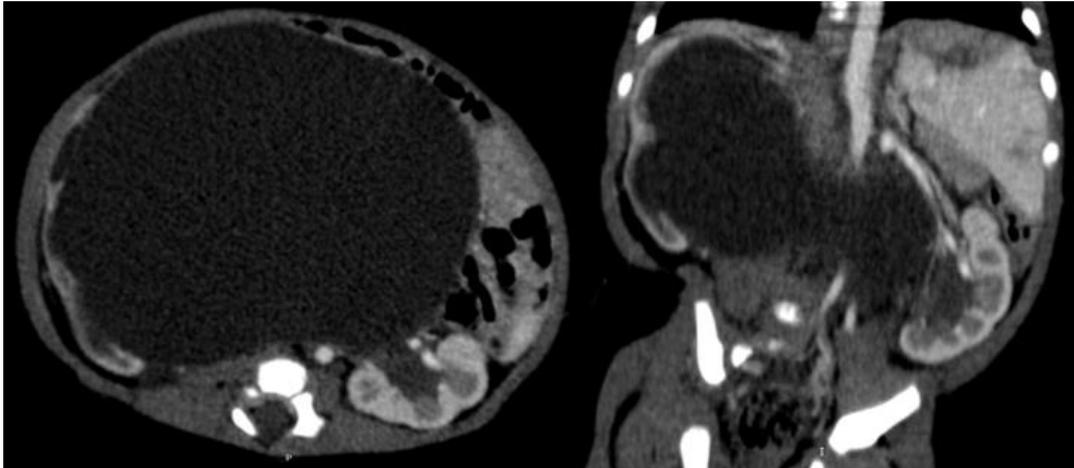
Axial (a) and coronal (b) Multiplanar CT portal venous phase contrast enhancement demonstrating a giant cystic mass occupying the right side of the abdomen and middleline
